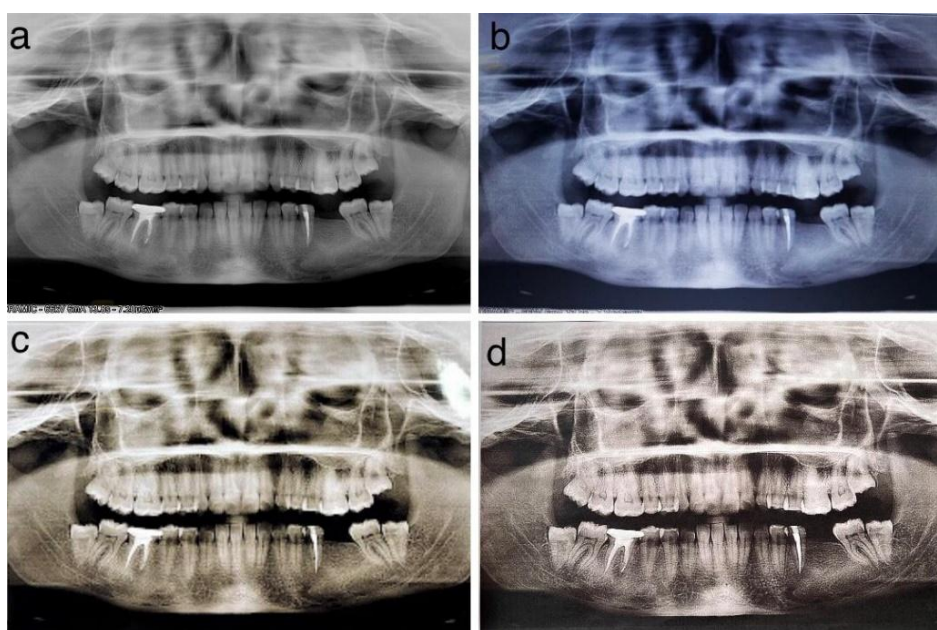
(a-d); Digital image, radiographic film, glossy paper, plain paper
